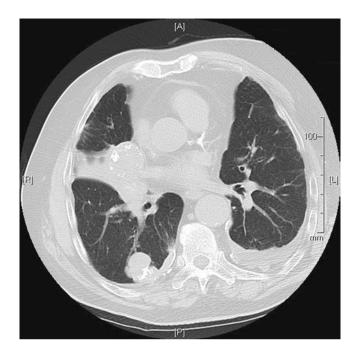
Non-contrast CT image of metastatic ossifying fibromyxoid tumor featuring pleural effusions, lung- and pleural-based metastases, and speckled calcification of the metastatic deposits
